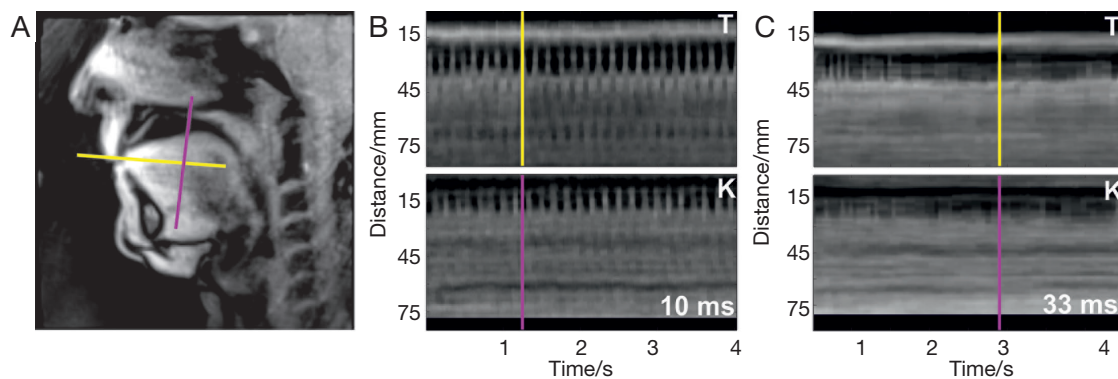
(A) Sagittal image selected from a real-time MRI movie at 100 fps indicating the position of the tongue tip for “T” (single subject). The two lines refer to the two major directions of tongue movement during double tonguing (repetitive “T”-“K” at top speed). Their signal intensity time courses are depicted for an image series at a nominal temporal resolution of (B) 10.0 ms and (C) 33.3 ms. MRI, magnetic resonance imaging; fps, frames per second.
